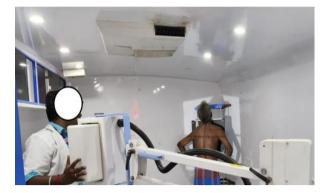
Chest X-ray being performed for a tuberculosis-suspect patient inside a mobile diagnostic unit.
